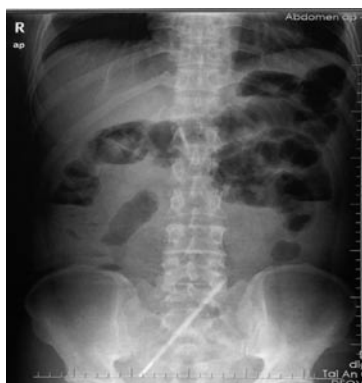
Abdominal X-ray showed dilation of the small intestines, gas-fluid levels and a thermometer-like object in the abdominal cavity.
